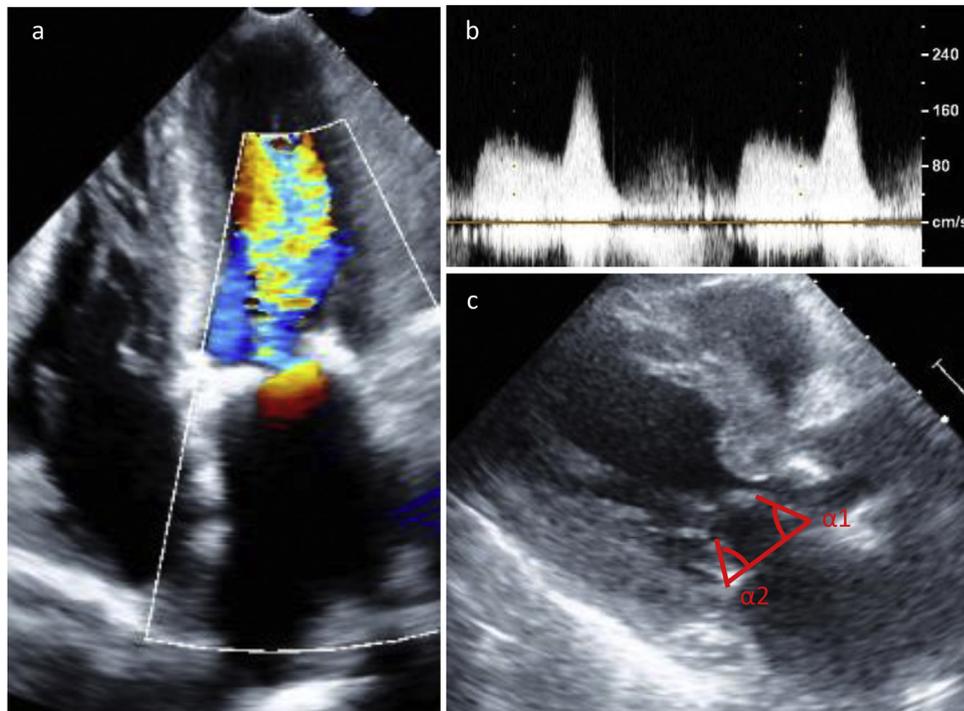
An example of mitral stenosis. Diastolic mitral jets with aliasing were identified with color Doppler in apical view (a) and Doppler diastolic mitral flow by continuous wave Doppler was recorded with transthoracic echocardiography (b). The angles between the anterior or posterior mitral leaflet and inner mitral annulus line ($\alpha 1$ and $\alpha 2$) were measured (c).
